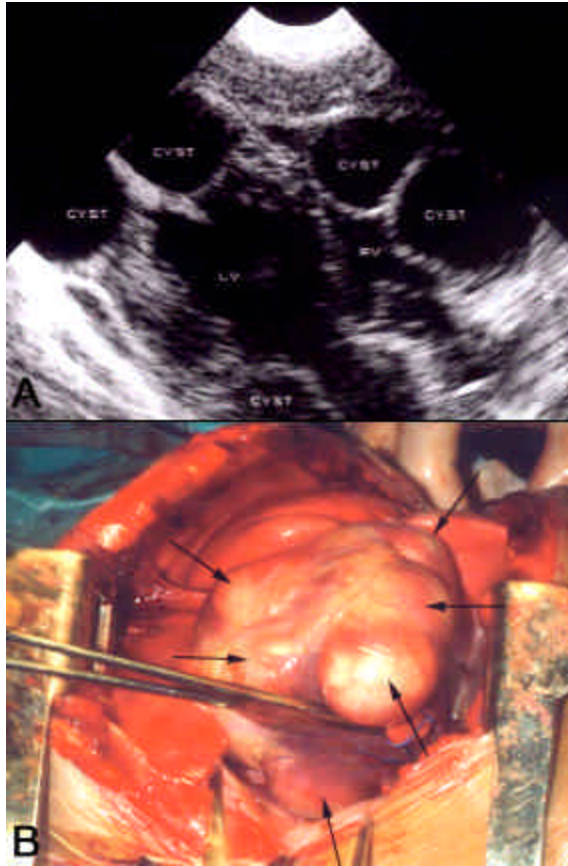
A. Echocardiogram demonstrating multiple hydatid cysts situated superficially in both ventricles. B. Intraoperative photograph demonstrating multiple hydatid cysts in the right and left ventricular walls. (Reprinted from reference 81 with permission of Dr. J.E. Bagg, Copyright 2002, Texas Heart Institute, Houston, TX).
